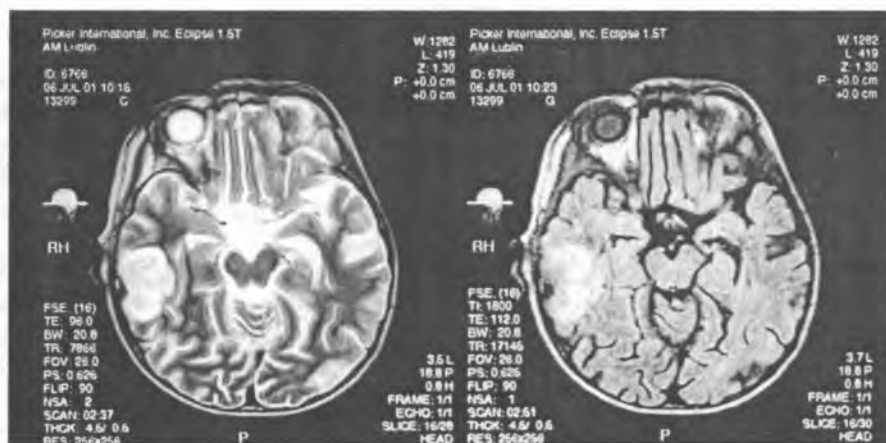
The intracranial lesion, caused by fungal infection, on magnetic resonance image from a male aged 4 years
